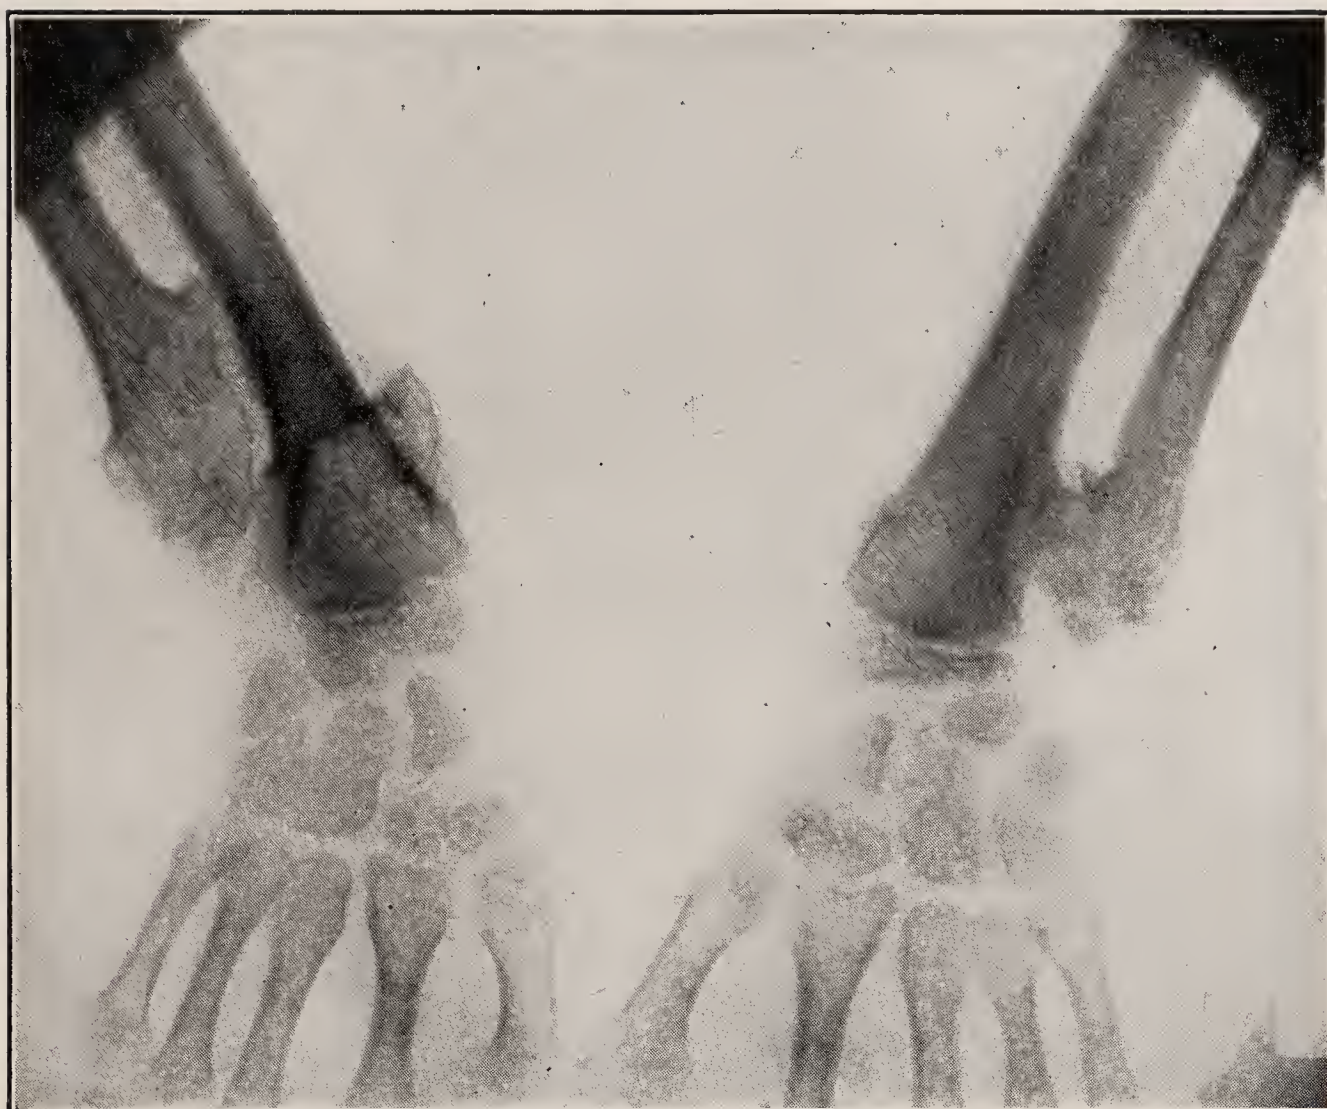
X-ray of dyschondroplasia showing appearances of wrists.
